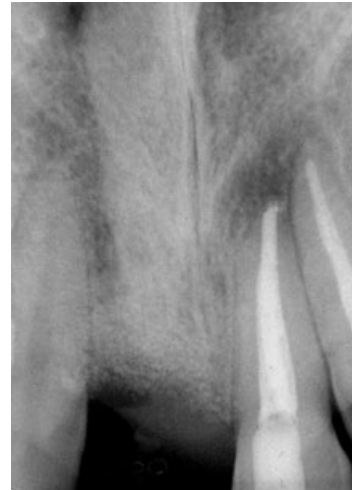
Follow-up radiograph taken 18 months following decoronation.
